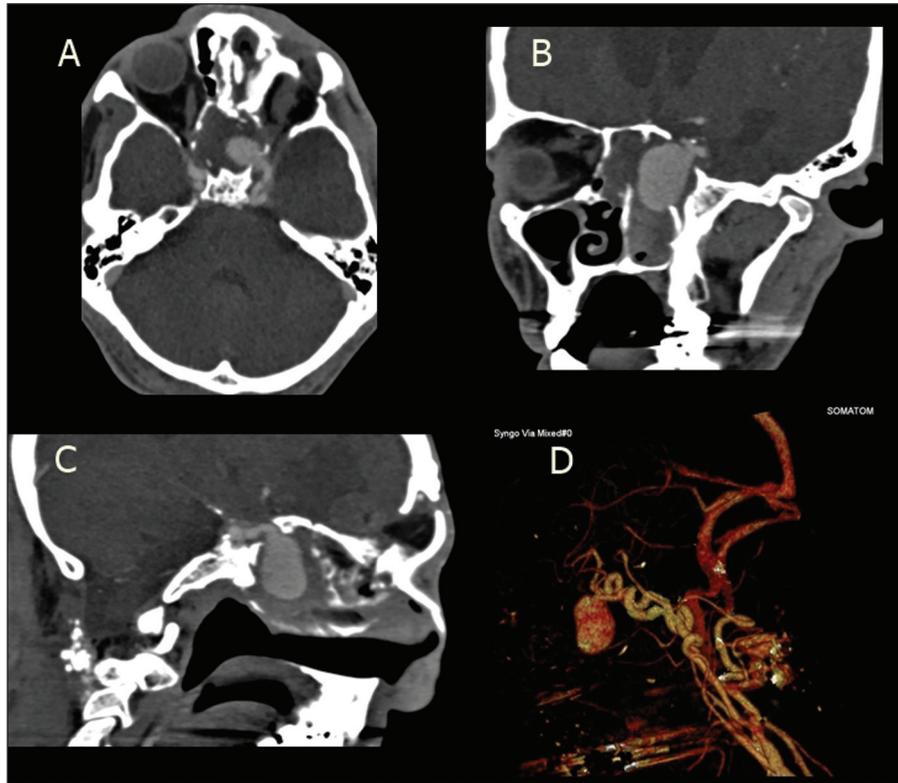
CT-Angiographic imaging of cavernous pseudoaneurysm, A) Axial section, B) Paracoronaral section, C) Parasagittal section, D) 3D colored reconstruction.
